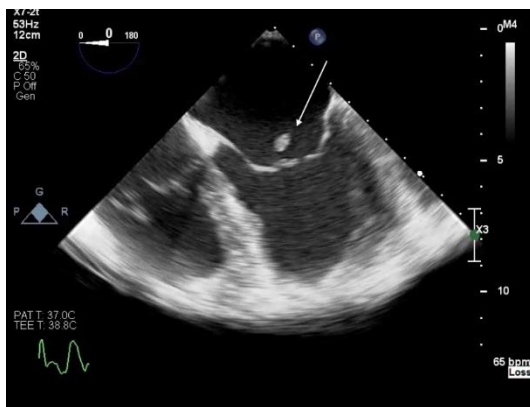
Transoesophageal echocardiogram demonstrating a mass attached to the tip anterior leaflet of the mitral valve (see arrow).
